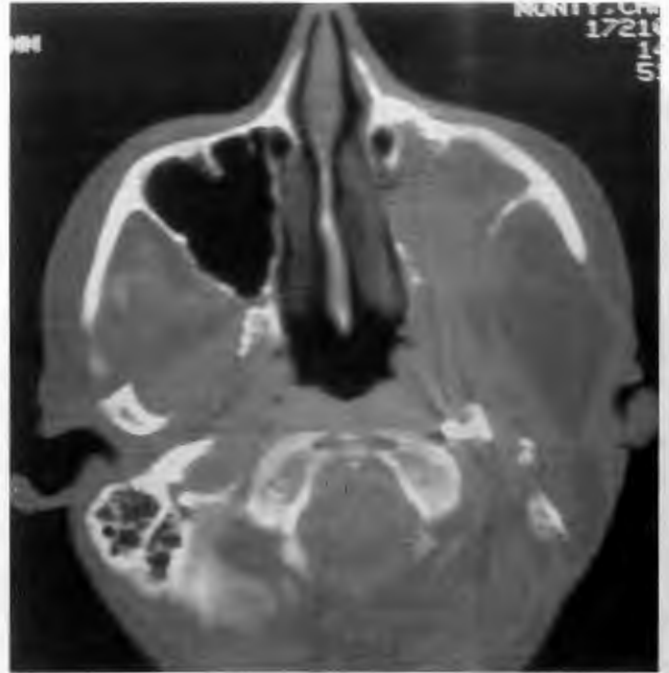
Bone window computed tomographic scan at 4 weeks after "combined technique" osteoplastic maxillotomy with free-flap reconstruction of skull base and temporal bone defects. Note symmetry of facial skeleton and restoration of nasal and nasopharyngeal anatomy.
